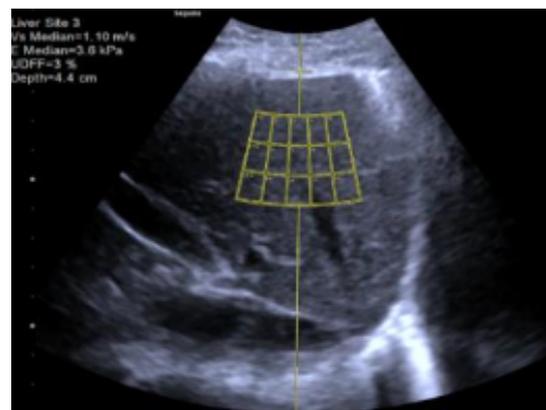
Ultrasound-derived fat fraction (UDFF) examination acquired using the Siemens Acuson Sequoia ultrasound system, displayed via the PACS system.
